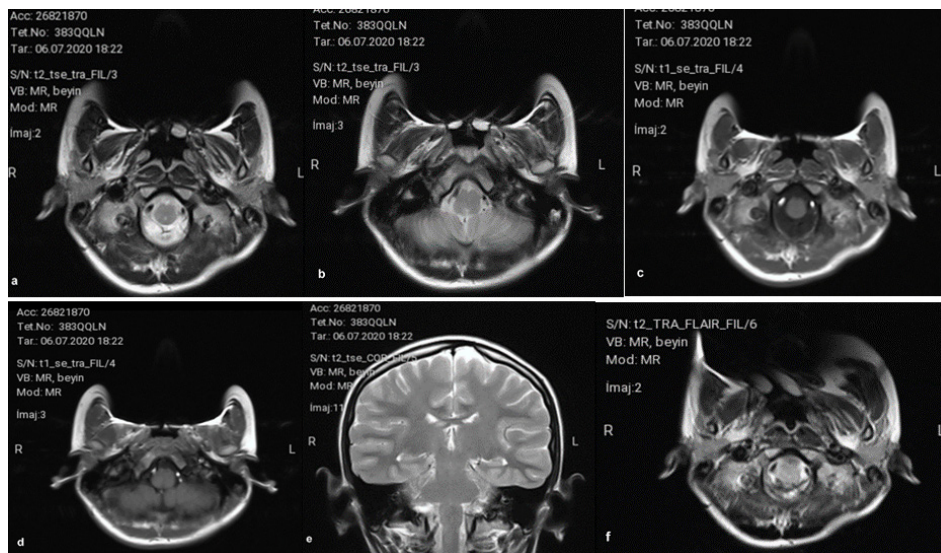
(a-b-c-d-e-f): Brain MRI showing the normal course of the hypoglossus nerve
